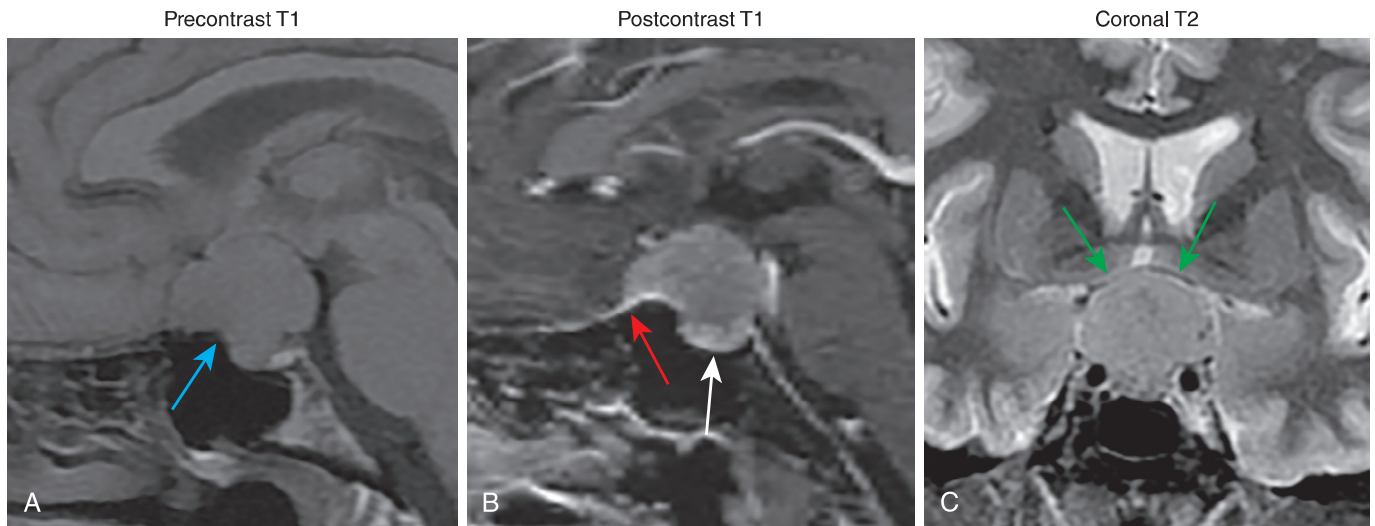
Suprasellar meningioma. A 50-year-old woman with headache. (A) Sagittal T1 precontrast magnetic resonance imaging (MRI) demonstrates a T1 isointense lesion (*blue arrow*) elevating the optic chiasm. Note: No expansion of the sella and normally positioned posterior pituitary bright spot. (B) Sagittal T1 postcontrast MRI demonstrates moderate lesion and dural tail enhancement over the planum sphenoidale (*red arrow*). Note normal enhancement of the anterior pituitary gland below the meningioma (*white arrow*). (C) Coronal T2 MRI demonstrates elevation and compression of the optic chiasm (*green arrows*).
